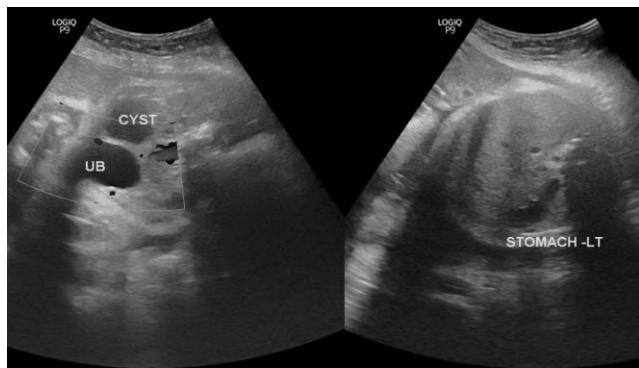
Antenatal ultrasound showing pelvic cyst measuring 3 x 3 cm adjacent to urinary bladder, probably ovarian origin
